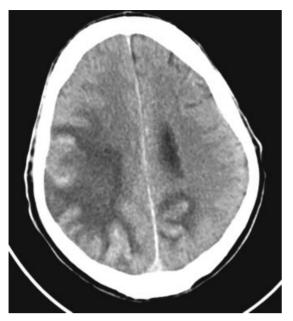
Case 1: Head computed tomography image showing bilateral hemorrhagic infarcts, much larger on the right (left side of figure).
